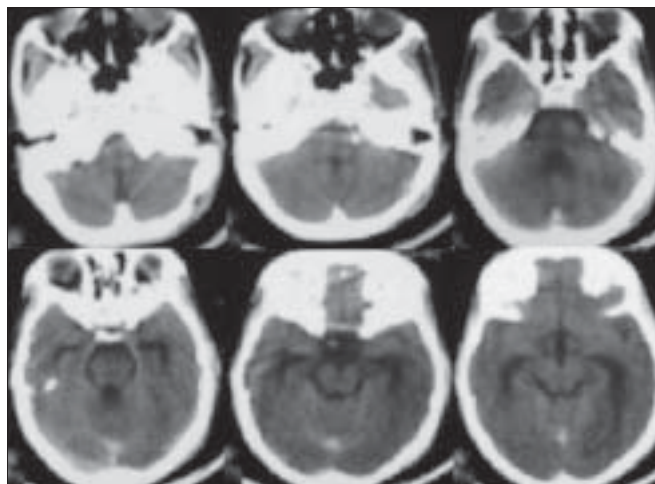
Post-operative CT scan showing complete aspiration of left cerebellar abscess
